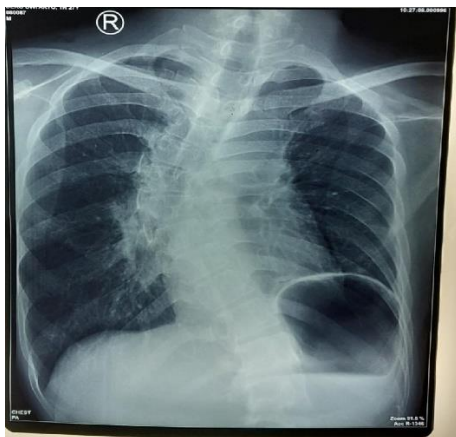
Chest X-ray post 4th cycle of chemotherapy
